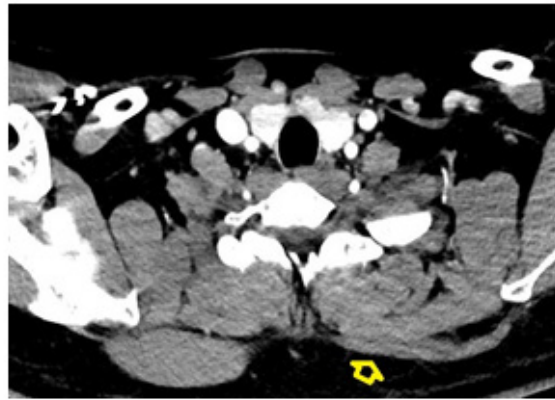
Axial CT image of the cervical and upper thoracic region demonstrates marked atrophy of the left trapezius muscle (yellow arrow) and showing trapezius volume loss and fatty infiltration. Consistent with denervation changes following spinal accessory nerve neurapraxia.
